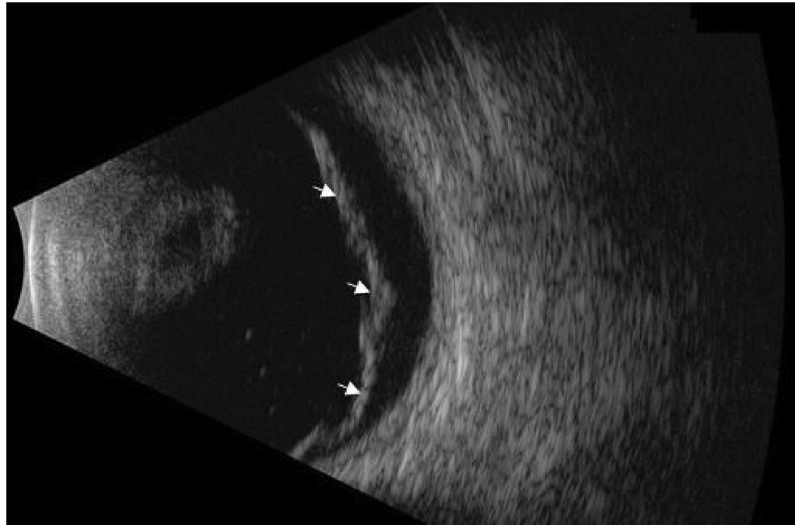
A male patient of 32 years old presents with sonographic features that are compatible with TRD (arrows).
